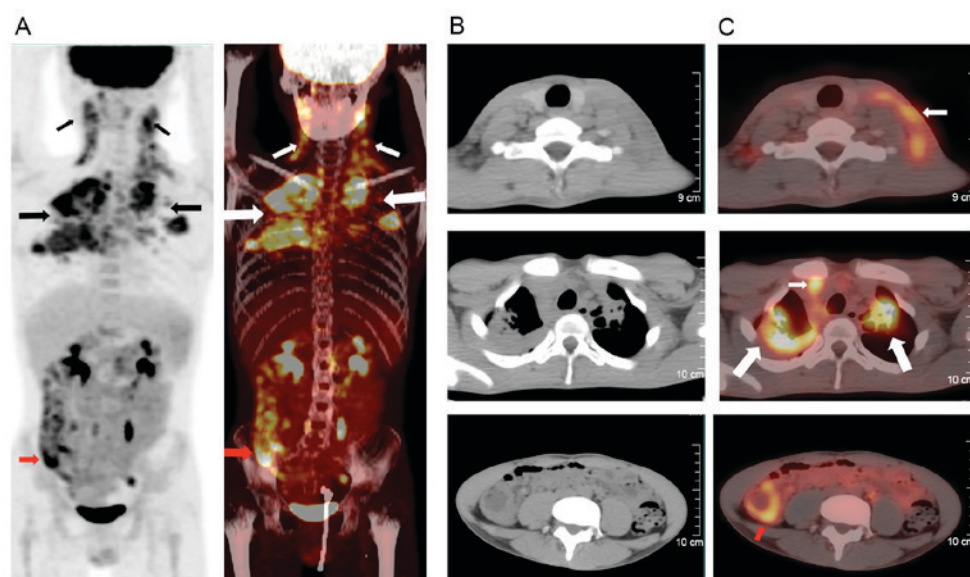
(A) Coronal FDG PET/CT image of the patient in case 2. (B) Axial CT images of the patient. (C) Axial PET/CT images of the patient. The images revealed enlarged lymph nodes with increased FDG uptake (SUV_{max} , 5.8) in the right parapharyngeal space, bilateral carotid sheath, cervical region, bilateral supraclavicular fossa and mediastina (smaller white arrows). A mass of cavitary phthisical lesions were also demonstrated in bilateral lung tissue, with an SUV_{max} of 6.8 (large white arrows). A thickened right ascending colon wall with increased FDG uptake (SUV_{max} , 6.0) was also detected (red arrows). FDG PET/CT, F-fluorodeoxyglucose positron emission/computed tomography; SUV, standard uptake value.
